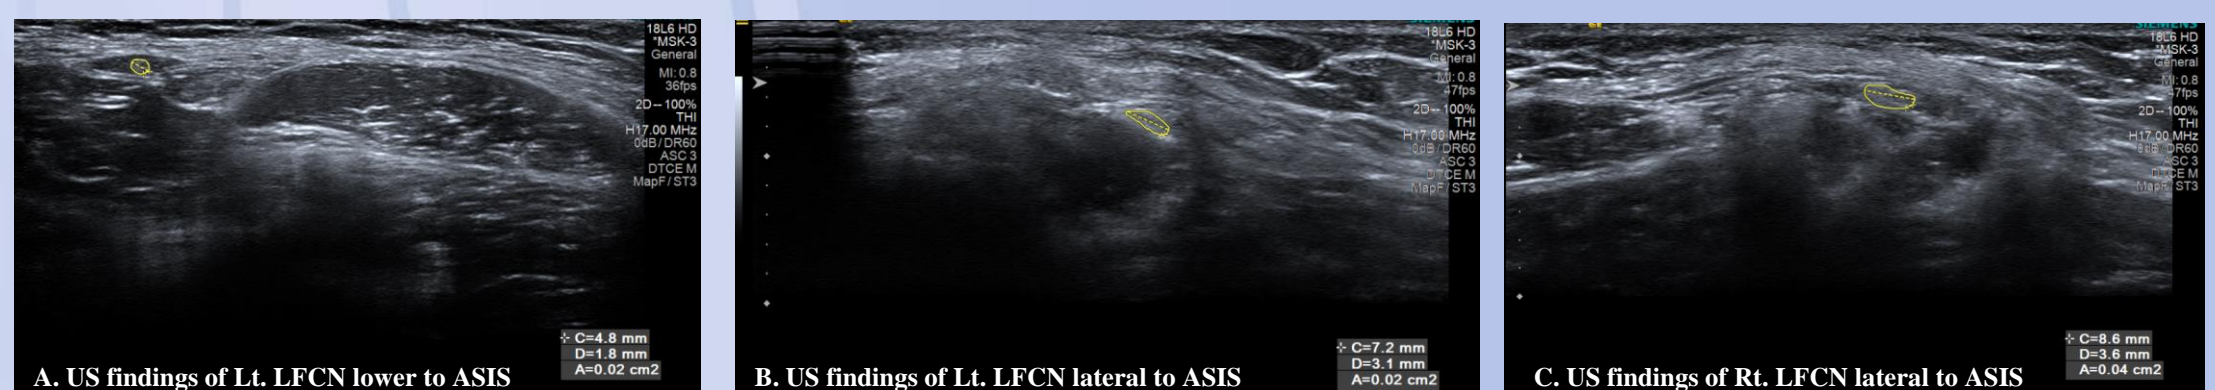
Ultrasonographic findings of LFCN
